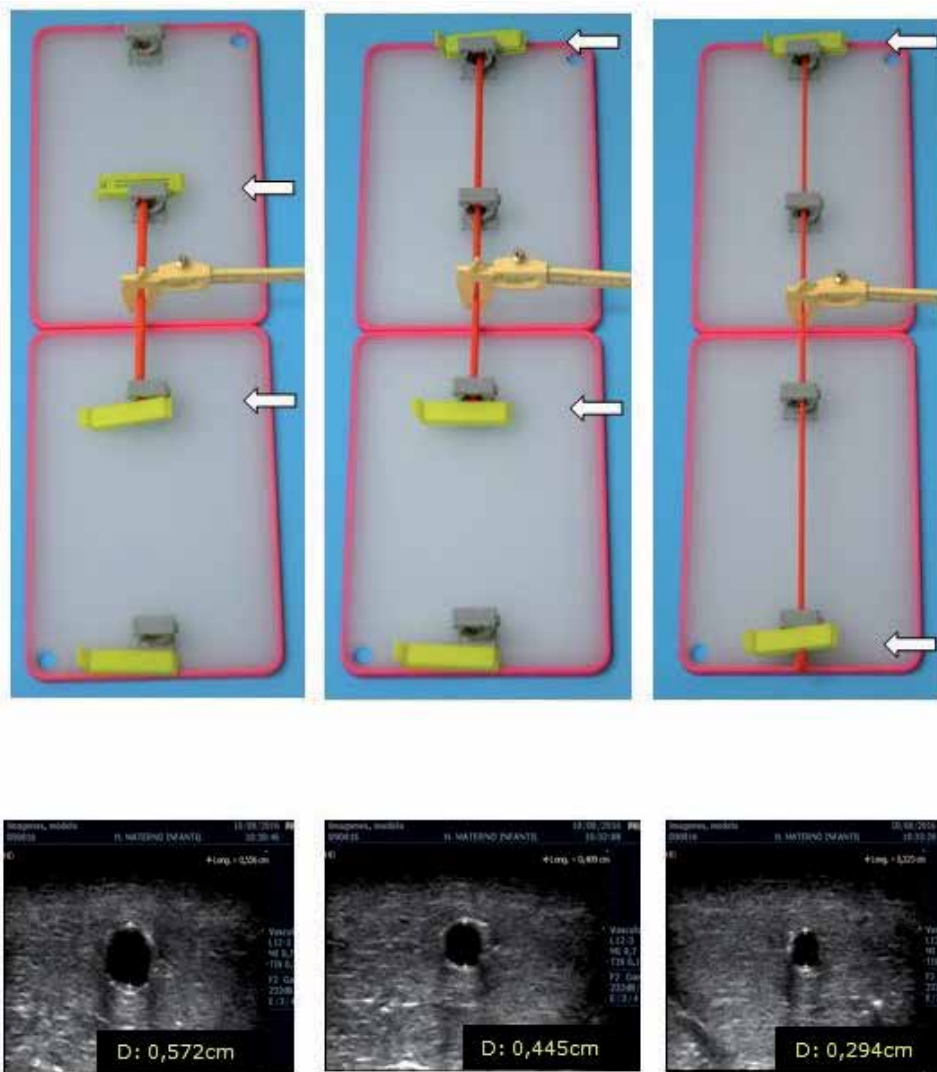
Vessel's diameters (D_1 – D_3) depending on the stretching degree of the elastic structure with its clamps (arrows) and their ultrasound representation.
